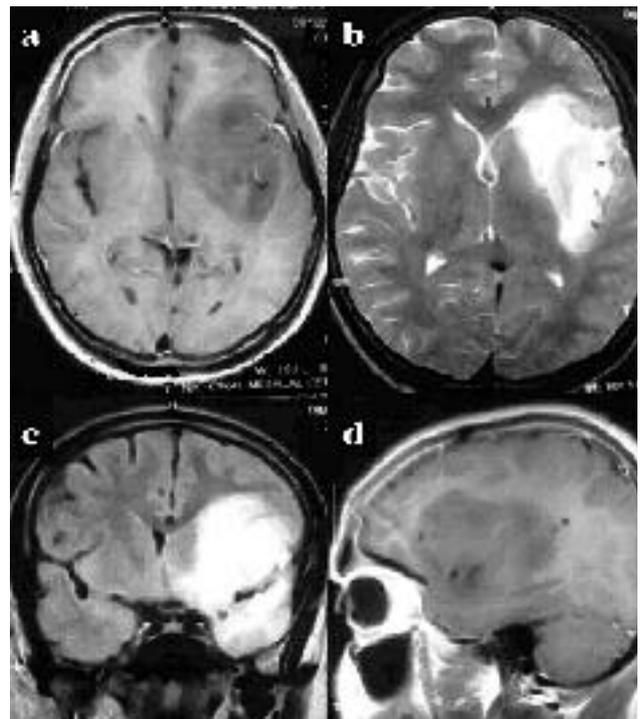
MRI of LGG present in the dominant hemisphere of a right-handed male, mainly in the insular and sub-insular region. The lesion does not enhance on contrast: (a) T1 weighted contrast-enhanced axial image; (b) T2 weighted axial image; (c) FLAIR coronal image; and (d) T1 weighted contrast-enhanced sagittal image.
